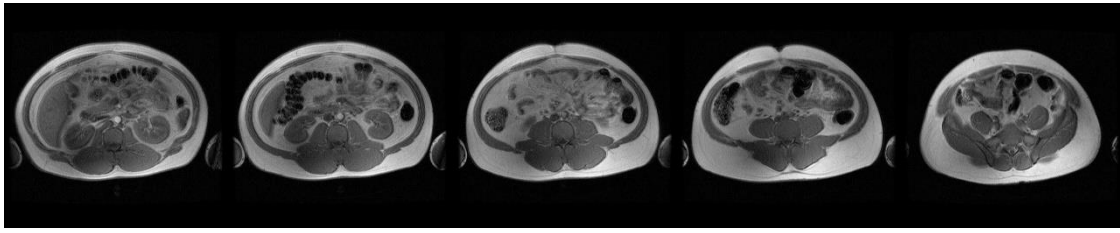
MR images showing abdominal adiposity obtained from a male subject. The images listed from left to right are located from the 1st lumbar vertebra (L1) to L5.
